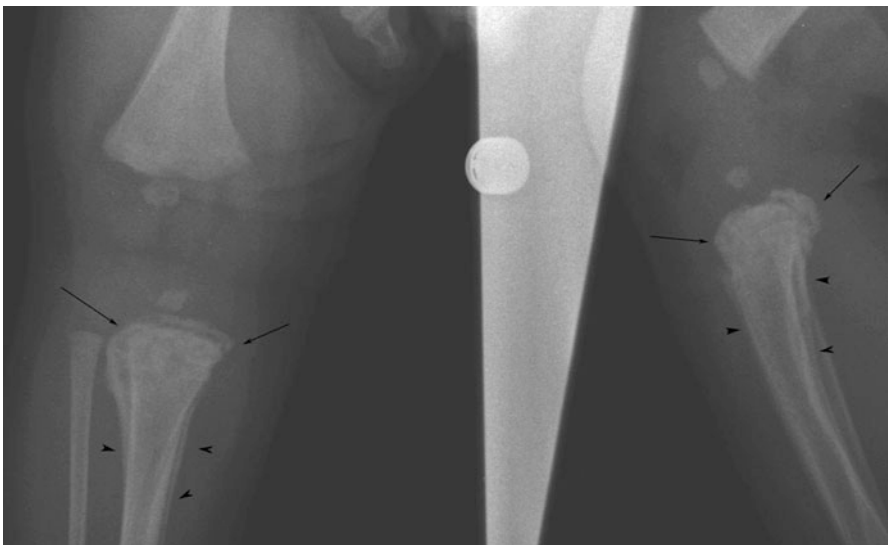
Frontal and lateral radiographs of the knee in an infant showing proximal tibial bucket-handle-type metaphyseal fracture (*arrows*) in the proximal tibia with subperiosteal new bone formation (*arrowheads*)
